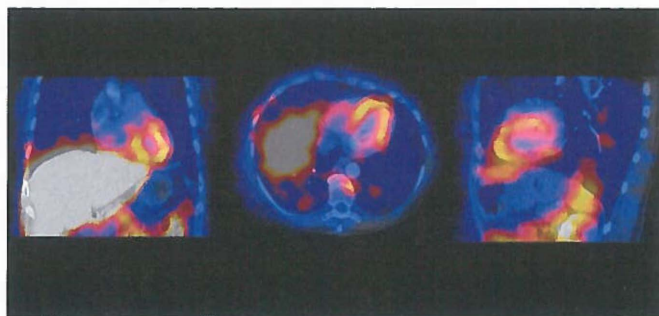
Fused computed tomography with ¹¹¹Indium-DTPA-trastuzumab single photon emission tomography (SPECT) image performed in a patient with metastatic osteosarcoma three weeks after 6 cycles after completion of doxorubicin (96 hours post tracer injection). Fusion of the images shows increased uptake of the tracer in the characteristic horseshoe shape of the myocardium of the left ventricle.
